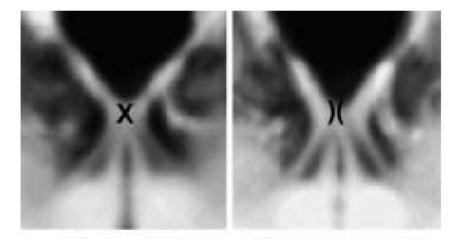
MRI pictures show the X-shaped chiasm in albinism on the left side, a normal)(-shaped chiasm on the right side.⁴⁰
